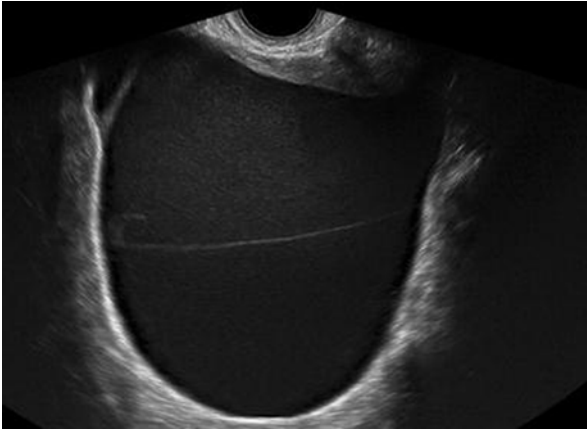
Mucinous cystadenoma by transvaginal ultrasound (Reprinted from Coccia et al. [74], Figure 9, with kind permission from Springer Science and Business Media)
